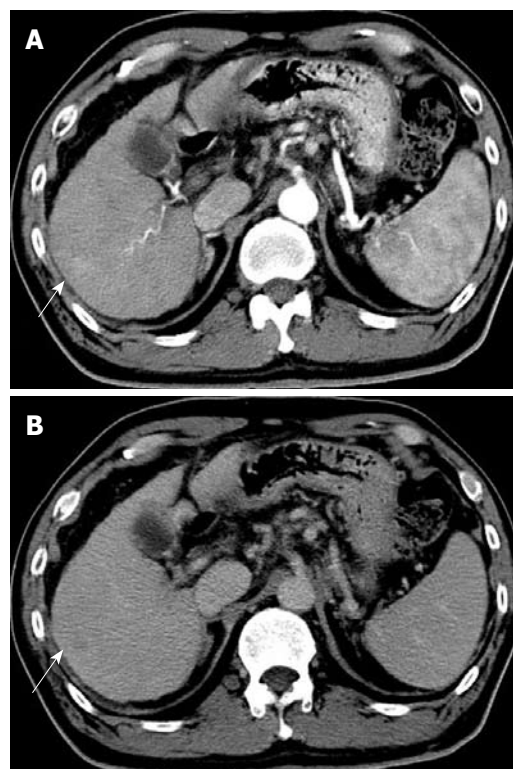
Contrast-enhanced CT. Heterogeneous, not diffuse, hypervascular nodule in the early phase (A) (arrow), and a low-density area in the late phase (B) (arrow).
